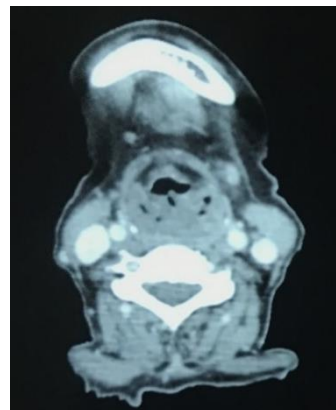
Axial view of CT image.
